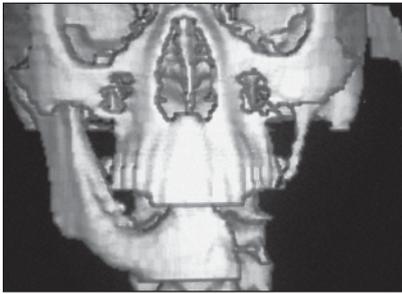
Computerized tomographic (CT) imaging of the bone defect 10 years ago, before the first reconstruction.
